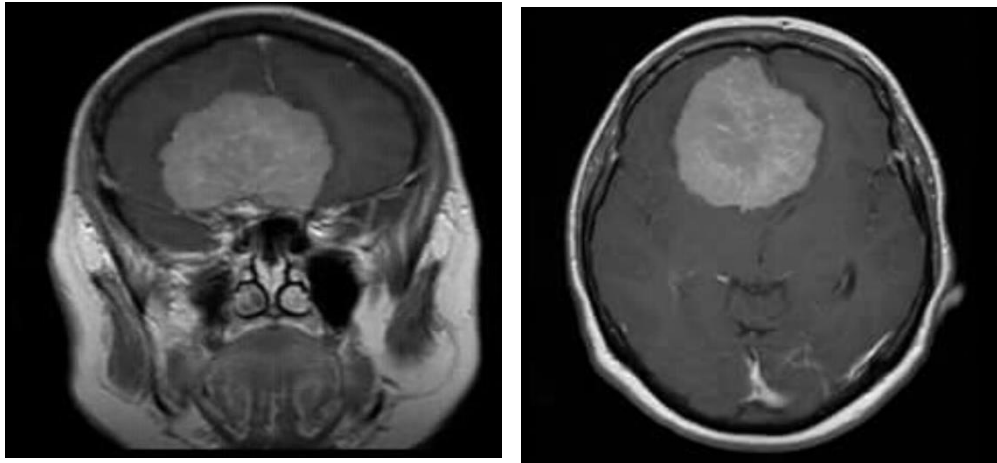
Preoperative MRI showing huge olfactory groove meningioma
